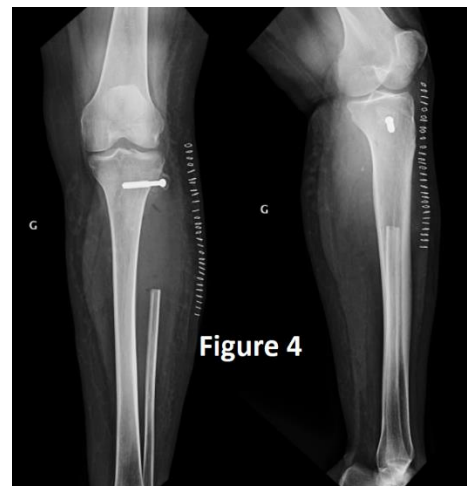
Frontal and lateral control radiograph showing the fibular head fixed with the tibia by a 55 mm screw to preserve the left lateral lateral ligament of the knee and insertion of the biceps femoris.
